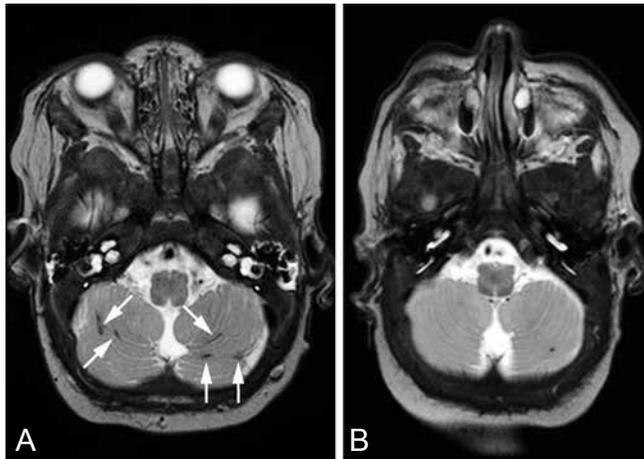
(A) T2-weighted MR image obtained at term age in a preterm male neonate born at 29 weeks GA. While CUS was normal, MRI showed multiple small streak-like hemorrhages in both cerebellar hemispheres (arrows). (B) T2-weighted MR image obtained at term age in a preterm female neonate born at 29 weeks GA. CUS was normal, MRI showed a single small hemorrhage in left cerebellar hemisphere.
